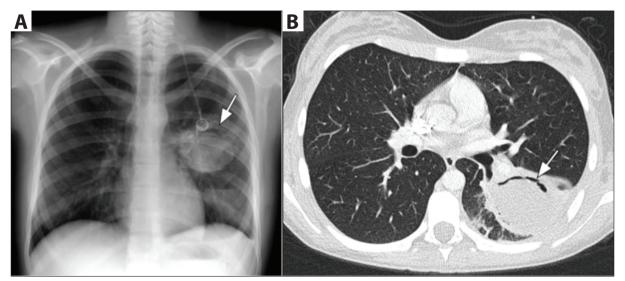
A. On the control posteroanterior chest radiograph taken six weeks later, there is a lucency (white arrow) consistent with the "air-crescent sign" in the nodule in the middle zone of the left lung. B. Transverse thoracic CT section shows the cavitary area (white arrow) representing the air-crescent sign.
